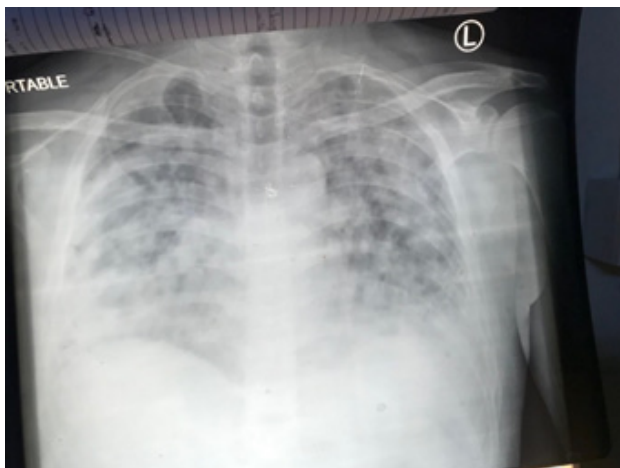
Plain chest radiograph showing bilateral heterogenous patchy opacities
